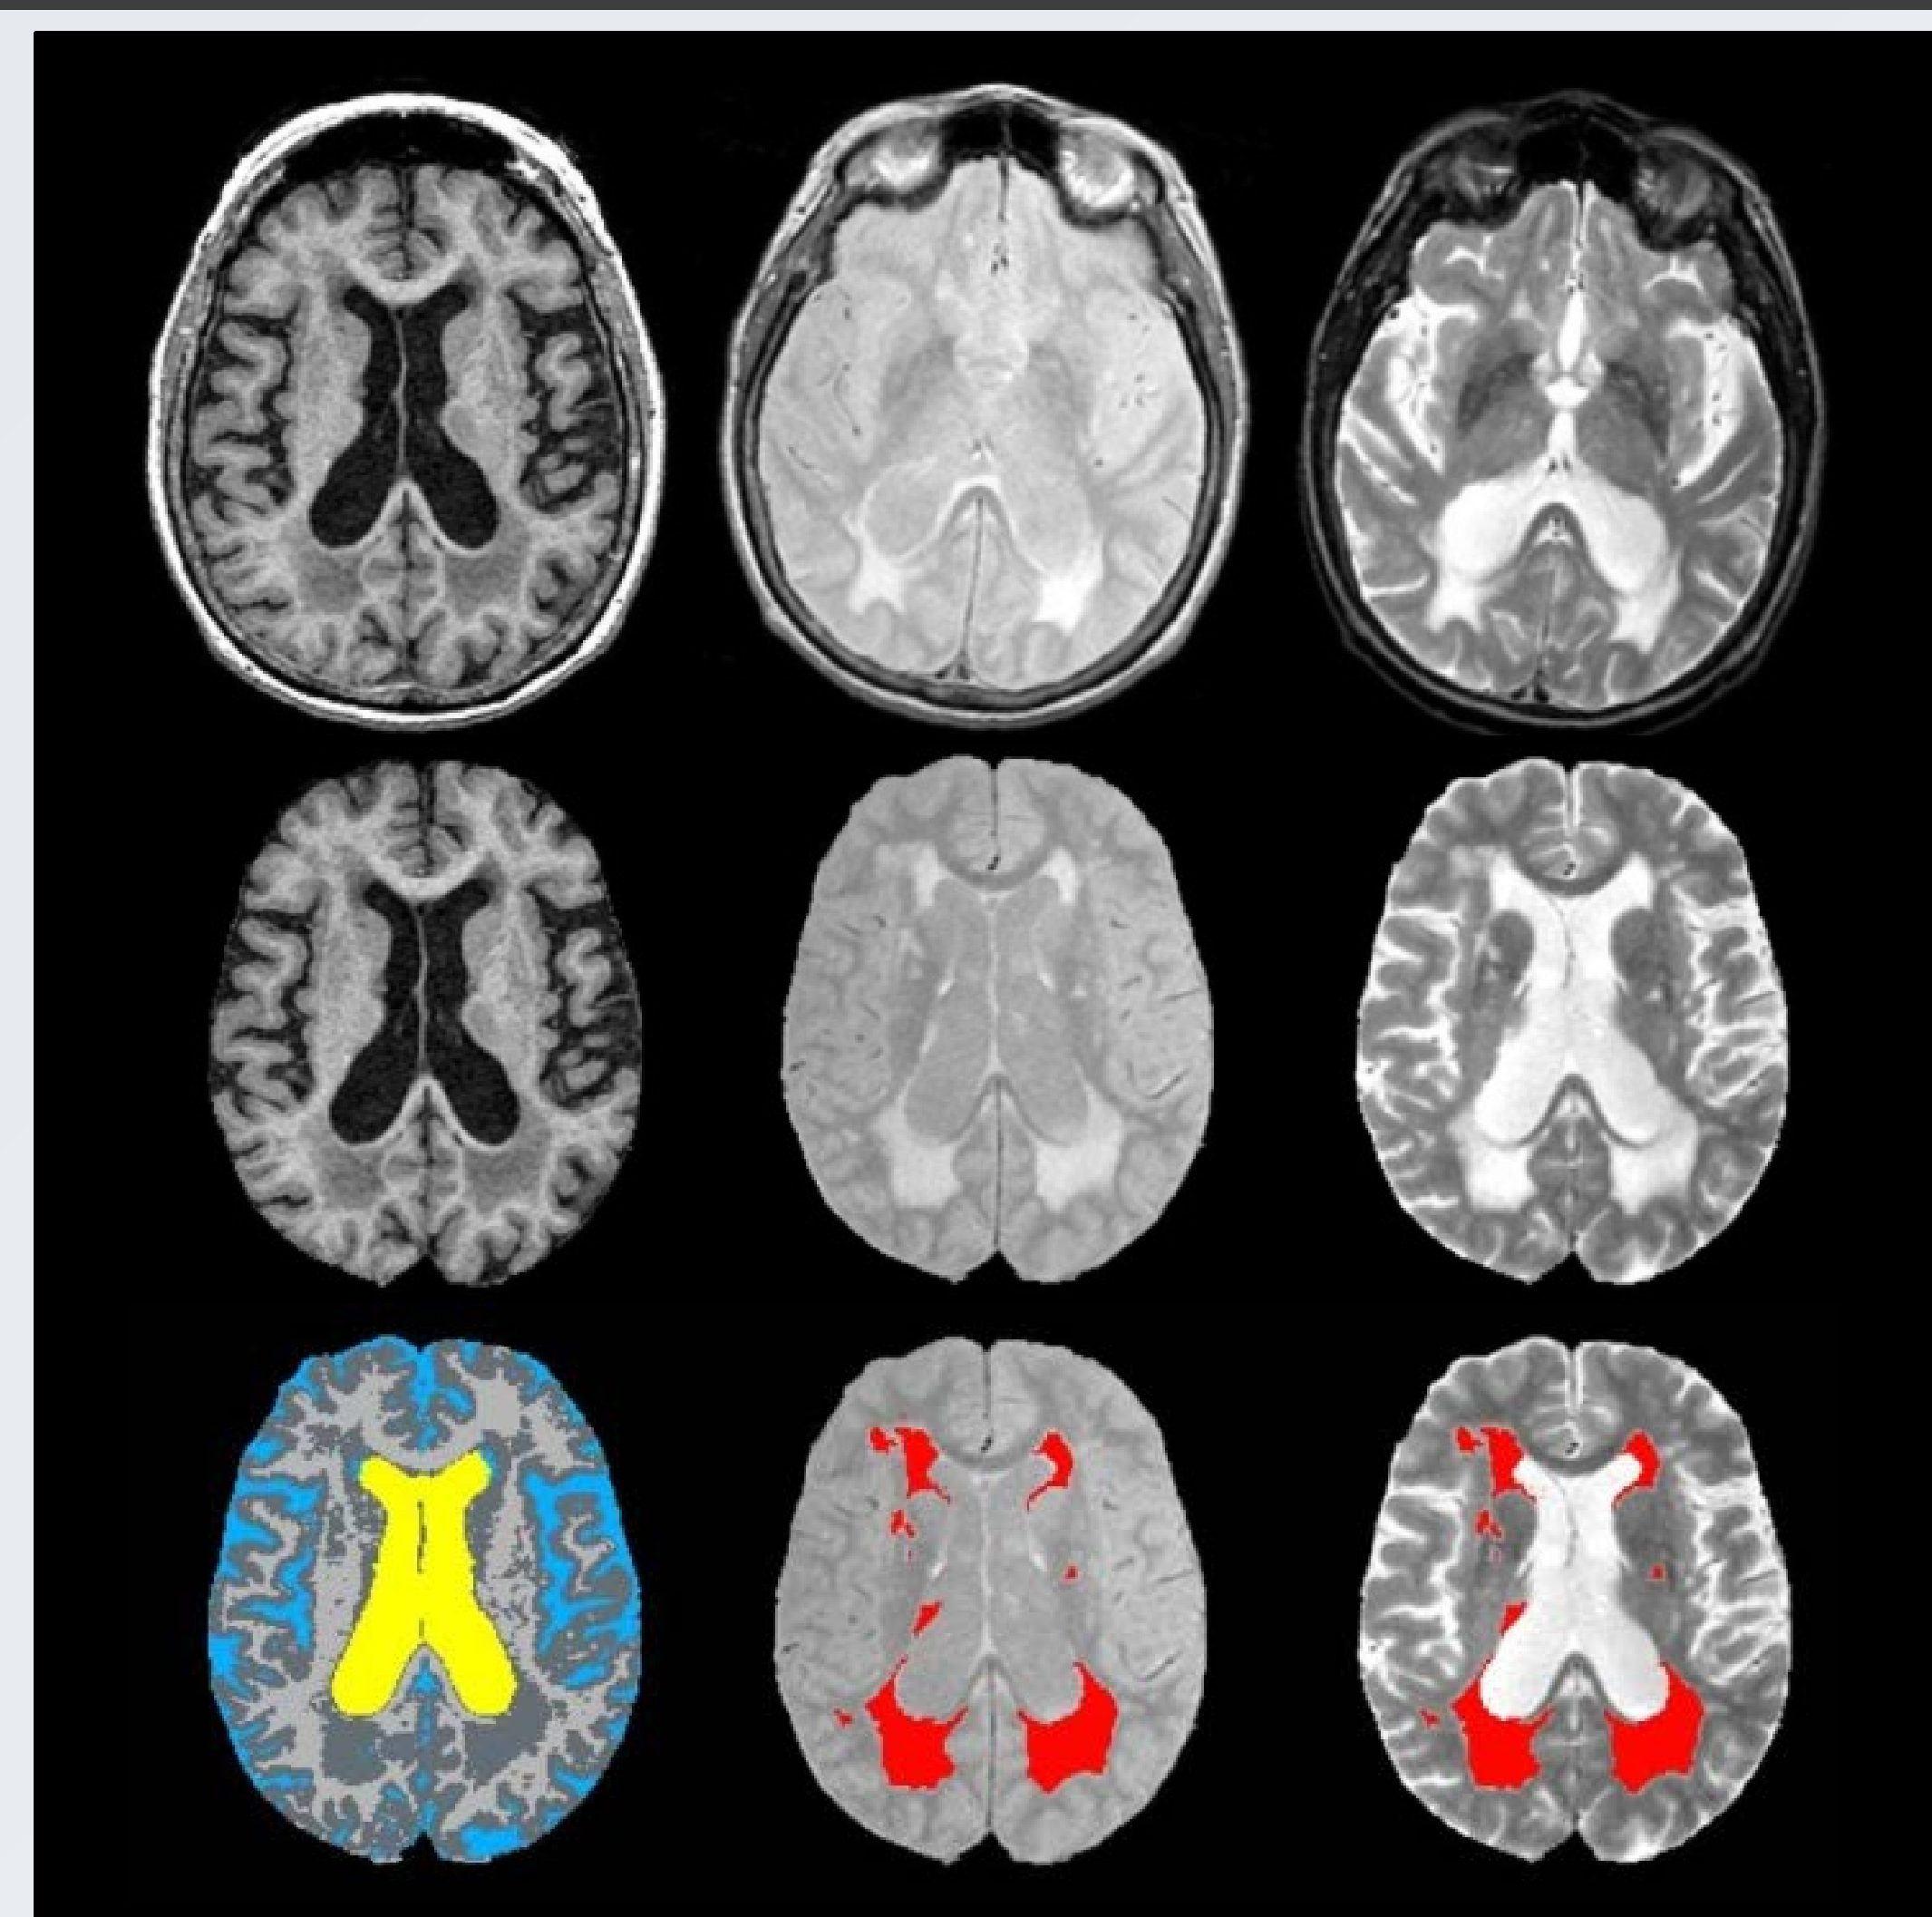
Visual representation of the LE MRI processing steps. T1 (left), PD (middle), and T2 (right), with SH segmentation overlaid in red.
